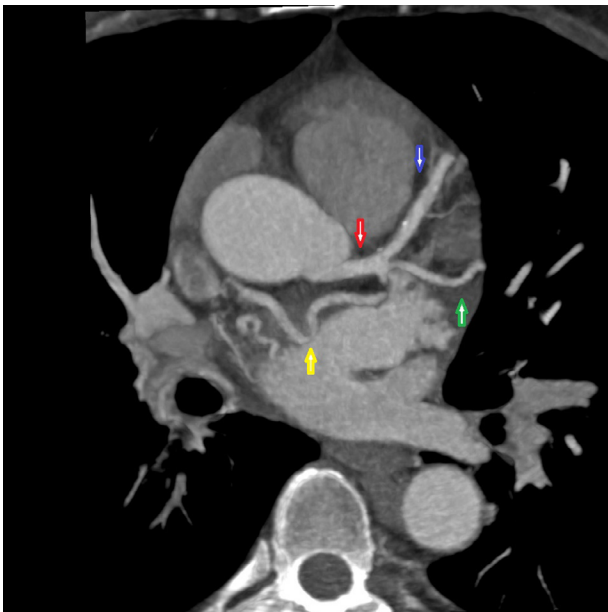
CT coronary angiogram showing a fistula originating from the common trunk of the left coronary artery, describing a tortuous path (Red arrow : common trunk, Blue arrow : the anterior interventricular artery, Green arrow : circumflex artery, Yellow arrow : fistula, white arrow : tortuous path with collateral circulation). (Color version of figure is available online.)
